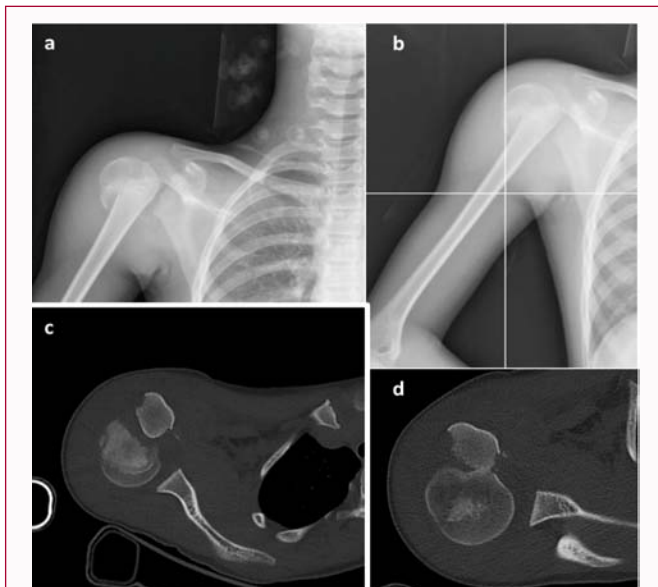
a, b) antero-posterior radiograph representative for clear diagnosis of S-H type II fracture; c, d) imaging appearance at axial CT scan of proximal humerus fracture.
